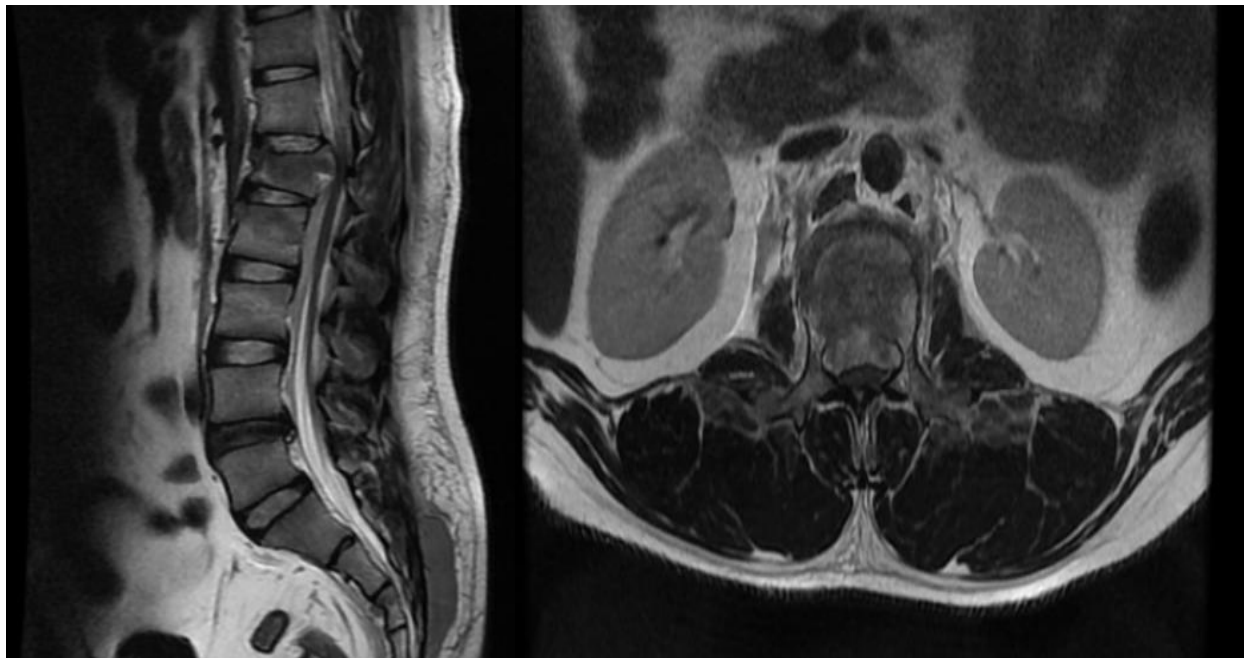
Pre-operative MRI of Lumbar vertebrae shows L1 burst compression fracture with compression over the spinal cord.
